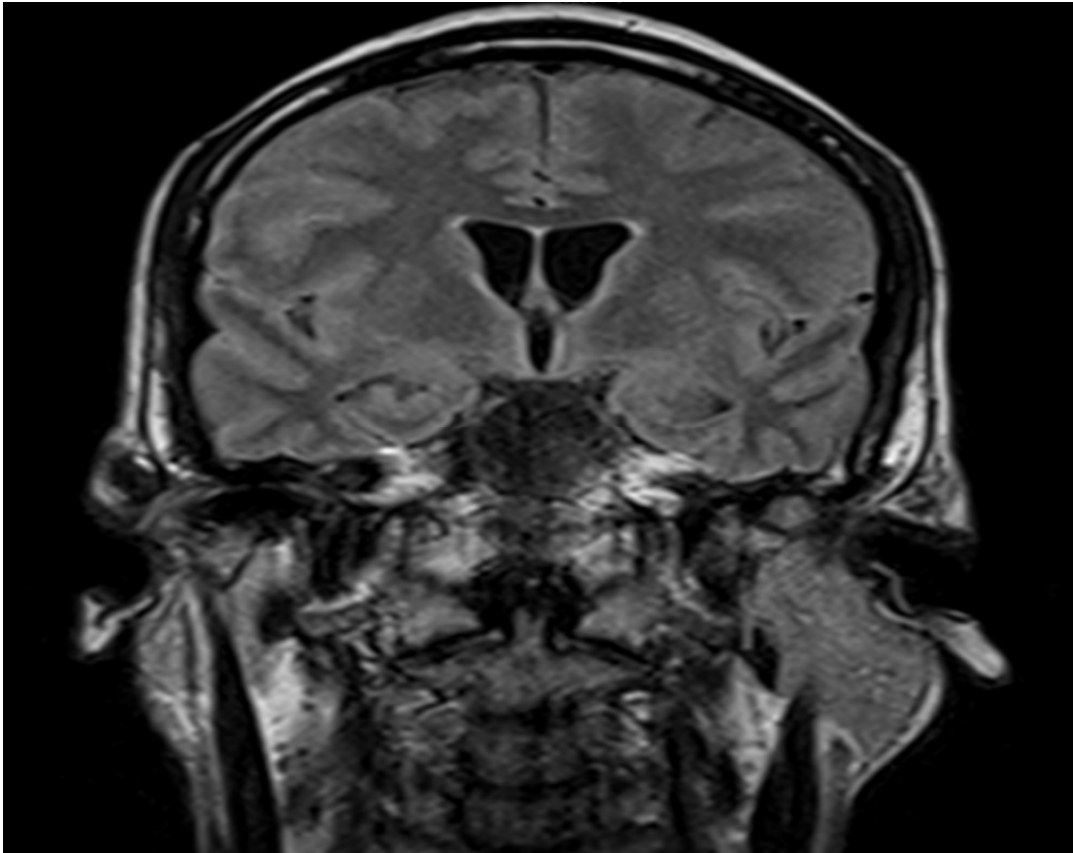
20 years old female admitted with diagnosis of meningitis. Coronal Unenhanced FLAIR image showing hyperintense signals in sulci and loss of normal CSF signals. Findings consistent with bacterial meningitis on Cerebrospinal fluid analysis
